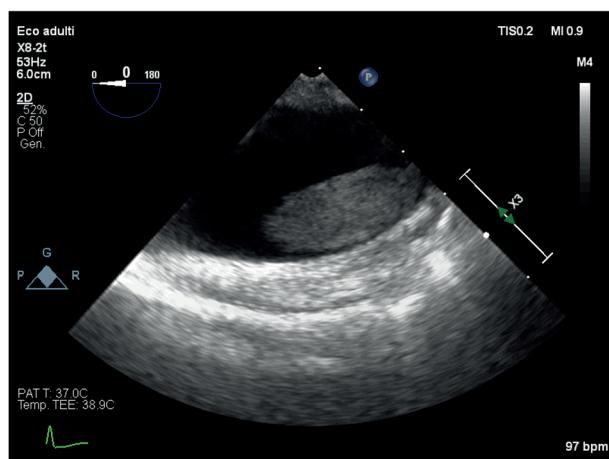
Trans-esophageal echocardiography showing aortic arch mural thrombus before thrombolysis treatment.
